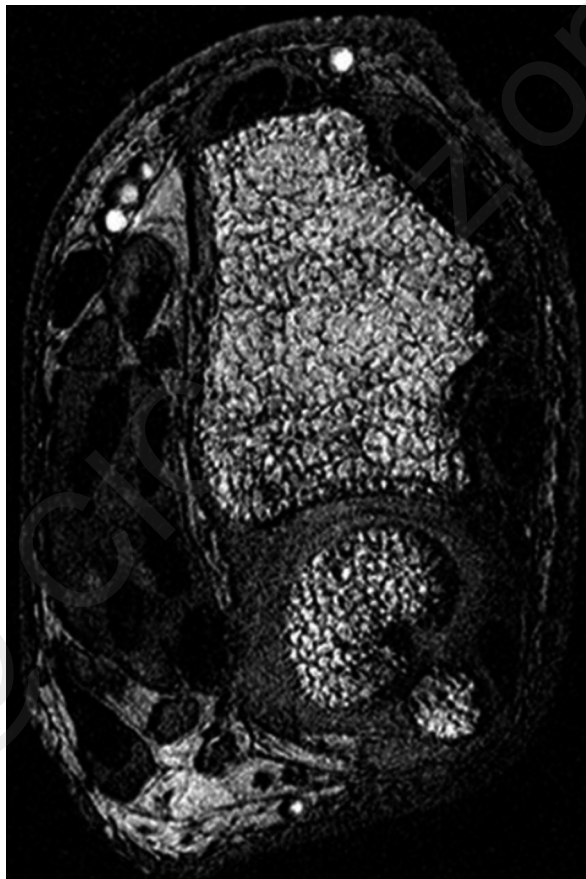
Representative MR image of the distal radius of a 62-year-old subject with AI intake.
